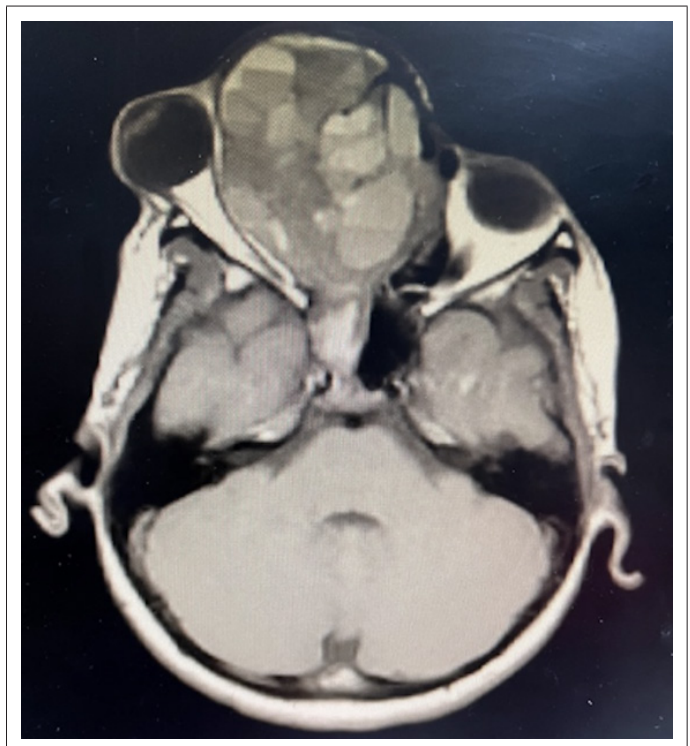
Axial computed tomography scan showing a lesion consistent with an aneurysmal bone cyst filling the left nasal cavity, causing destruction of the frontal bone, medial walls and roofs of both orbits, ethmoid bone, anterior wall of the right sphenoid sinus, bilateral nasal bones, maxilla, and hard palate. The lesion extends intracranially into the frontal region, contains both cystic and solid components with fluid–fluid levels, and displaces the right orbit laterally and out of the cavity.
